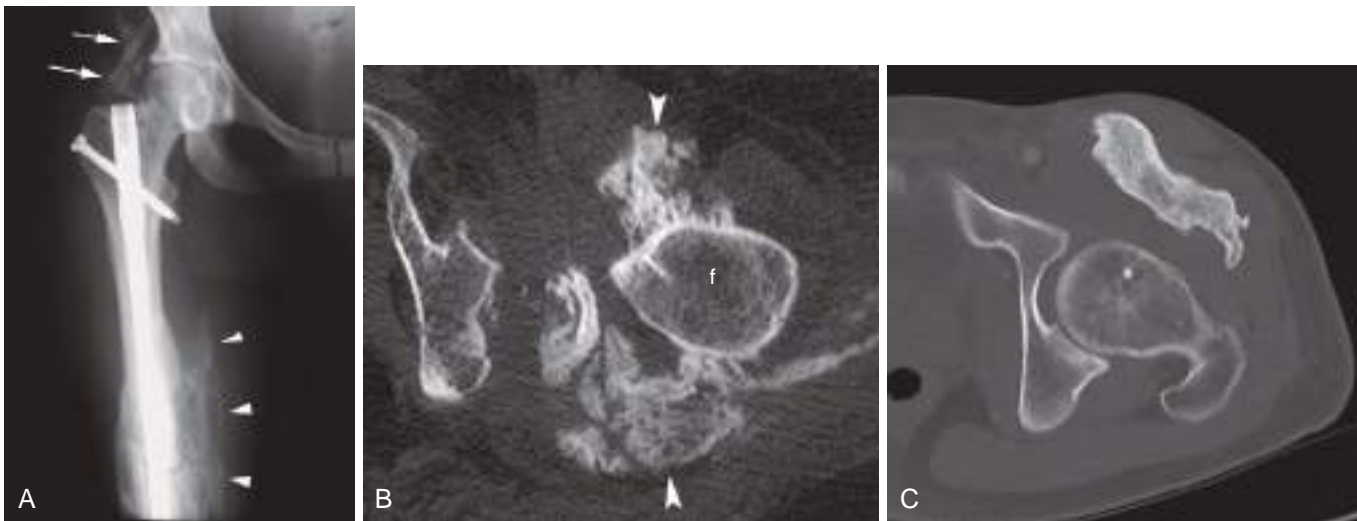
Posttraumatic heterotopic ossification. (A) AP radiograph of the right thigh and hip shows mature bone above the femoral neck (arrows) and medial thigh (arrowheads). (B) Heterotopic ossification (arrowheads) surrounding chronically dislocated left hip. (C) Heterotopic ossification anterior to the proximal left femur. *f*, Proximal femur.
